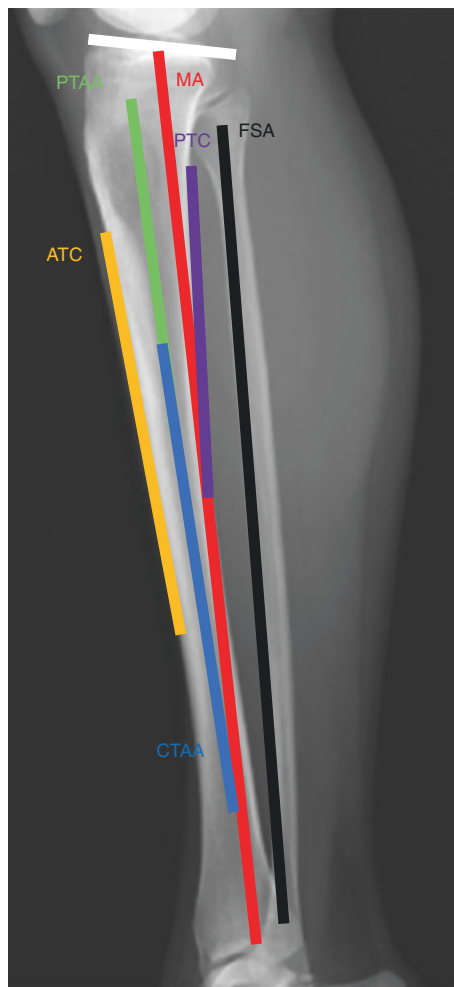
Different anatomical references for PTS measurement: ATC anterior tibial cortex, PTA proximal tibial axis, CTA central tibial axis, MA mechanical axis, PTC posterior tibial cortex, FA fibular axis
